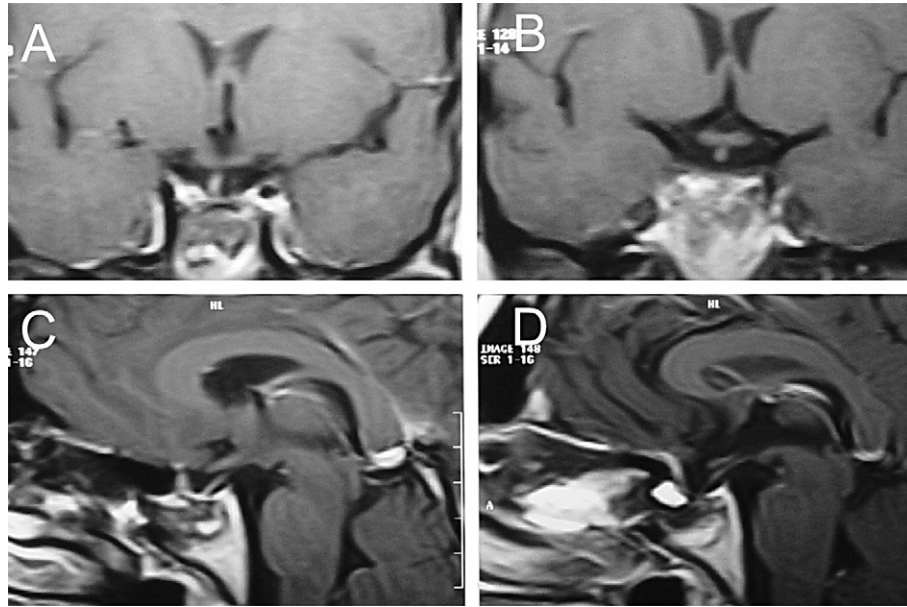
Postoperative coronal (A,B) and sagittal (C,D) T1-weighted MRI with contrast. Note the normal appearance of the pituitary stalk and diaphragma sella.
